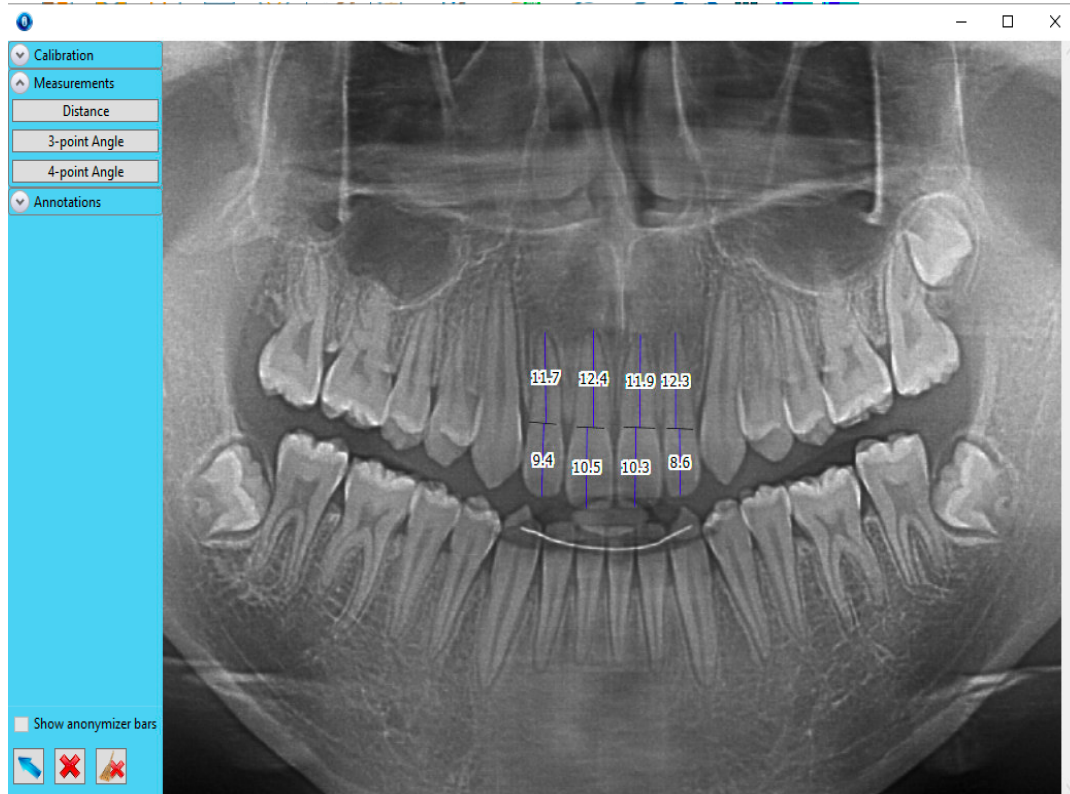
Final panoramic radiograph measurements
